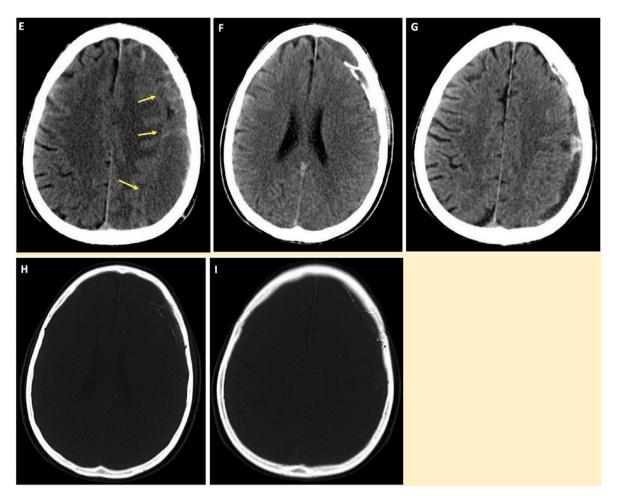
E. Non-contrast CT brain demonstrating a chronic left subdural hematoma (yellow arrows) with a mixed attenuation that features multiple loculated compartments filled with different stages of evolution with 1.9 cm of maximal thickness and 8 mm of left-to-right MLS. Figure F–G. Post-procedure non-contrast CT head scan (brain window) showing n-BCA within the septations and membrane of the chronic subdural hematoma. Figure H–I. Post-procedure non-contrast CT head scan (bone window) demonstrating n-BCA in the septations.
